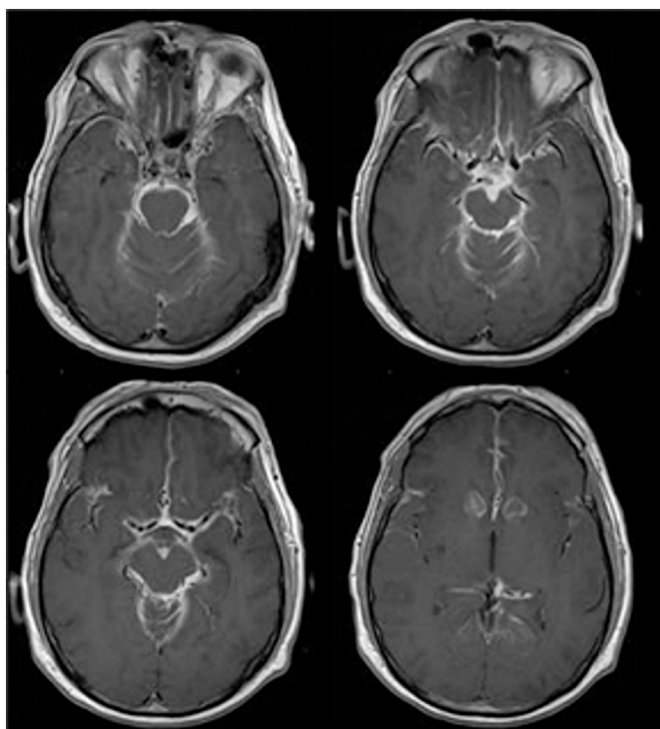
Axial Gd-enhanced T1-weighted magnetic resonance images of the brain 10 days after inadvertent intrathecal daunomycin administration, demonstrating diffuse abnormal leptomeningeal enhancement at the base of the skull, Sylvian fissures, and anterior interhemispheric fissure. There is also signal abnormality at the nuclei accumbens in the basal ganglia regions.
